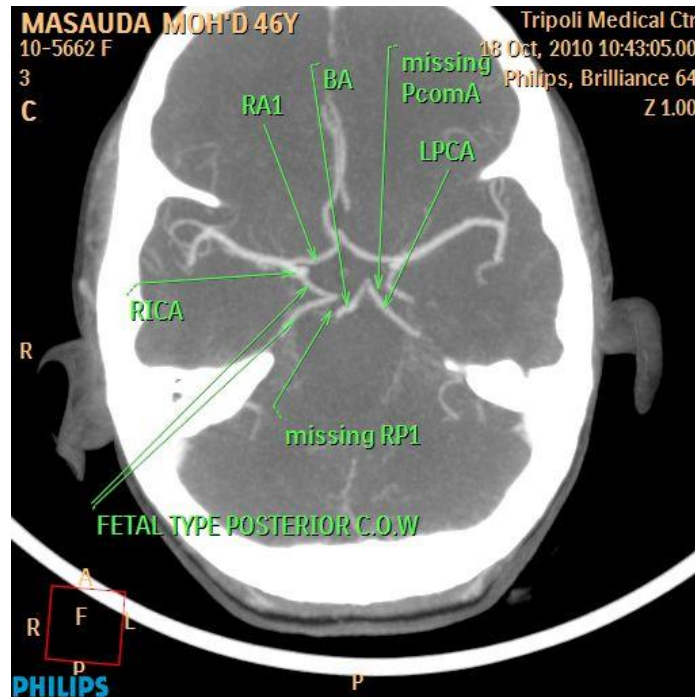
CTA shows Rt. complete FTP and missing LPcomA.
